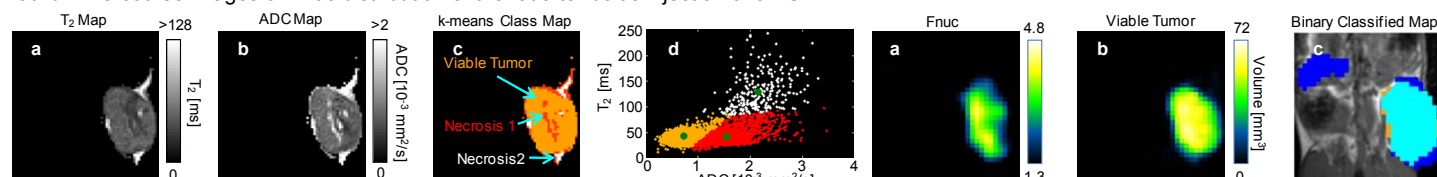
Results of evaluation of tumor status by using ^1H -MRI. a: T_2 map of the tumor for segmentation. b: ADC map of the tumor for segmentation. c: k-means class map of the tumor segmented into viable tissue (orange), necrosis 1 (red), and necrosis 2 (white). d: Cluster plots of the parameters used in the classification. Plot colors are the same as those in Fig. 2c.
